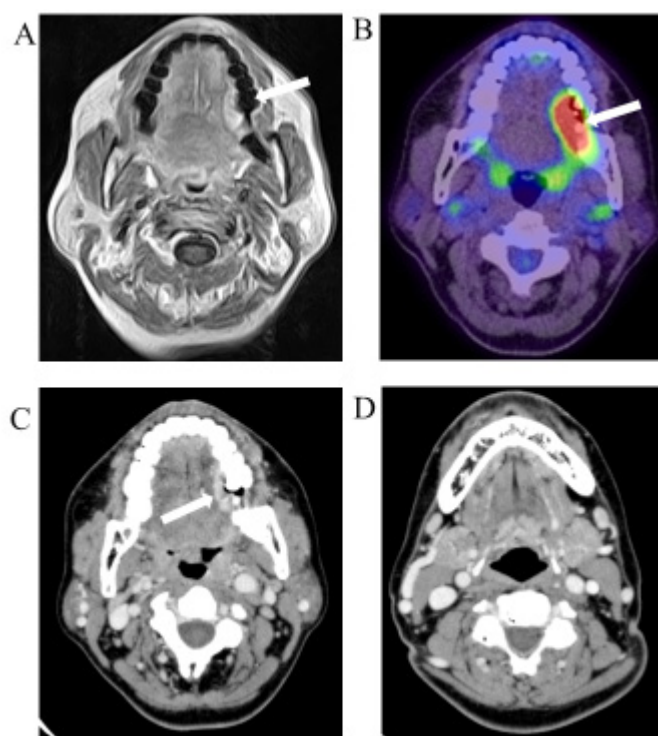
Magnetic resonance imaging showing a mass of tumor that has spread to the left tongue near the center (A, arrow). ¹⁸F-fluorodeoxyglucose (FDG)-positron emission tomography-computed tomography imaging revealed abnormal uptake of FDG (maximum standardized uptake value = 15.1) of the left tongue (B, arrow). Enhanced computed tomography image showing a tumor mass that has spread to the left tongue near the center (C, arrow). Intensified computed tomography image showing no metastases to the cervical lymph nodes (D).
